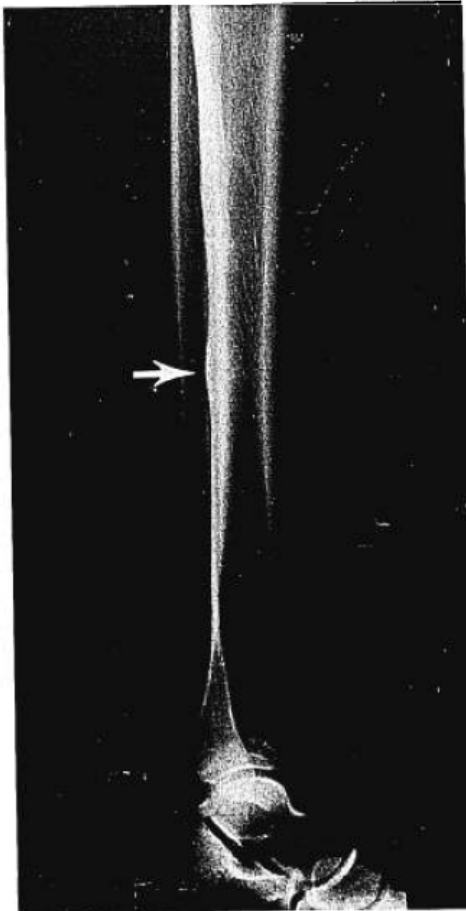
(Patient 23) Lateral roentgenogram of right tibia shows linear periosteal new bone formation (stress reaction) in middle third of diaphysis, as well as stress fracture (arrow) in posterior midshaft.
